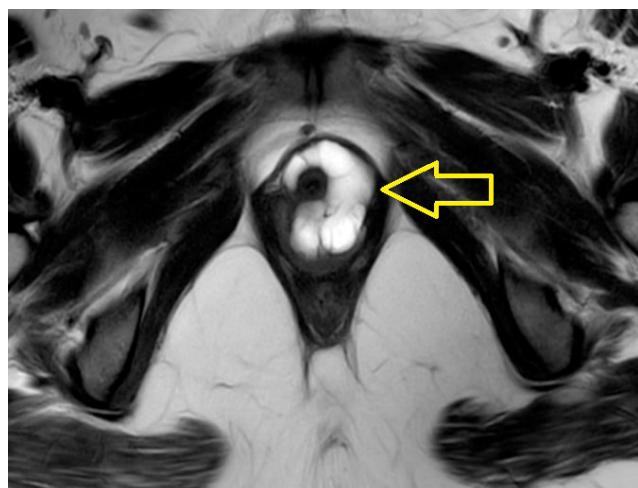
T2-weighted axial magnetic resonance imaging demonstrates a well-demarcated multiseptated periurethral cystic lesion encircling the urethra, with a characteristic saddle-bag configuration.
